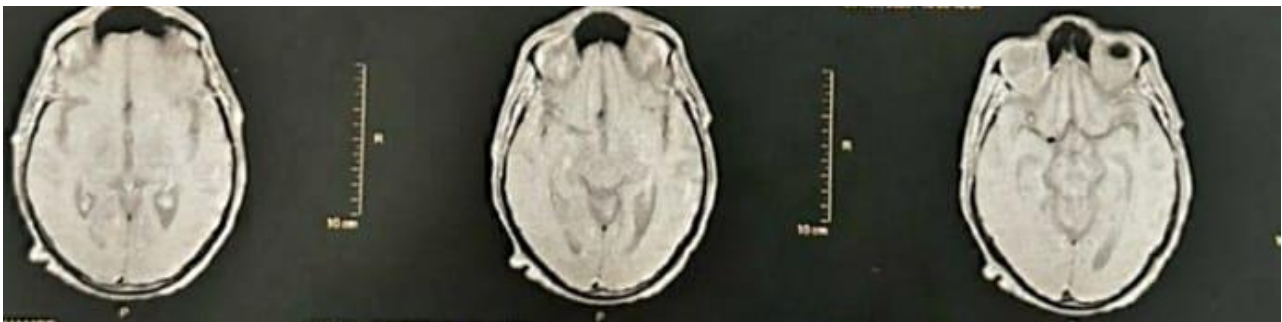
Axial FLAIR MRI sequences showing multiple hyperintense lesions suggestive of septic emboli
